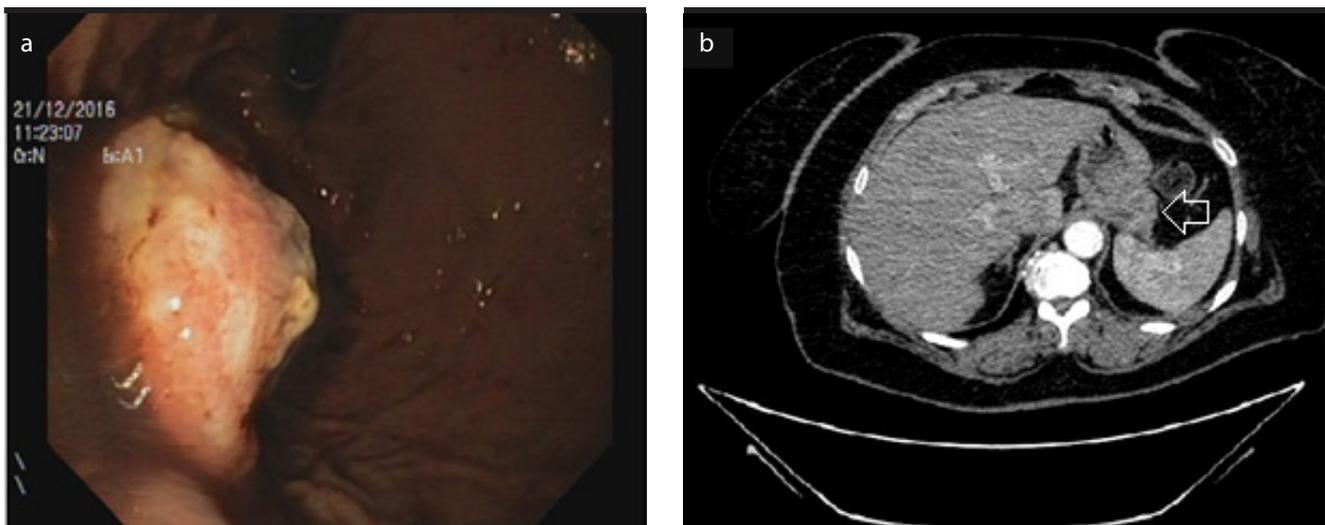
a, b. Endoscopic view showing a bleeding polypoid lesion of the stomach (a); abdominal computed tomography scan revealed a focal thickness of the gastric posterior wall (b) (white arrow).
